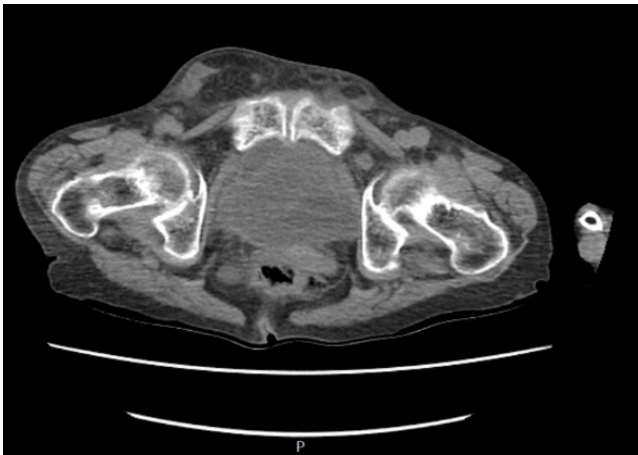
Obturator hernia view on abdominal computed tomography.
